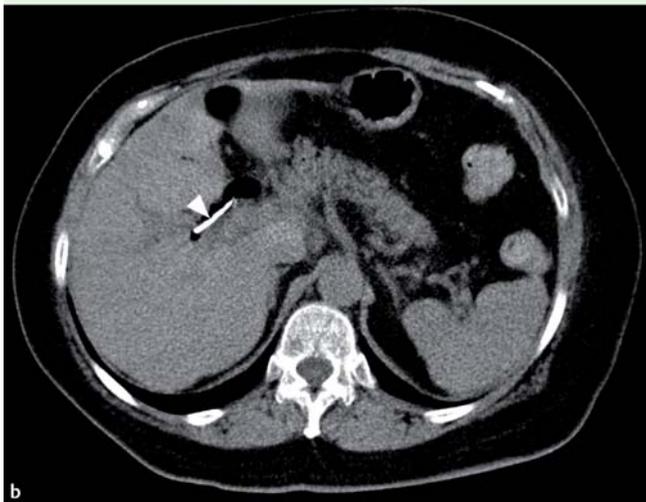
a Computed tomography (CT) scan of the abdomen on the day of the procedure shows the pancreatic duct stent at the head of the pancreas. b After 2 months, the stent was seen within the right intrahepatic duct.
